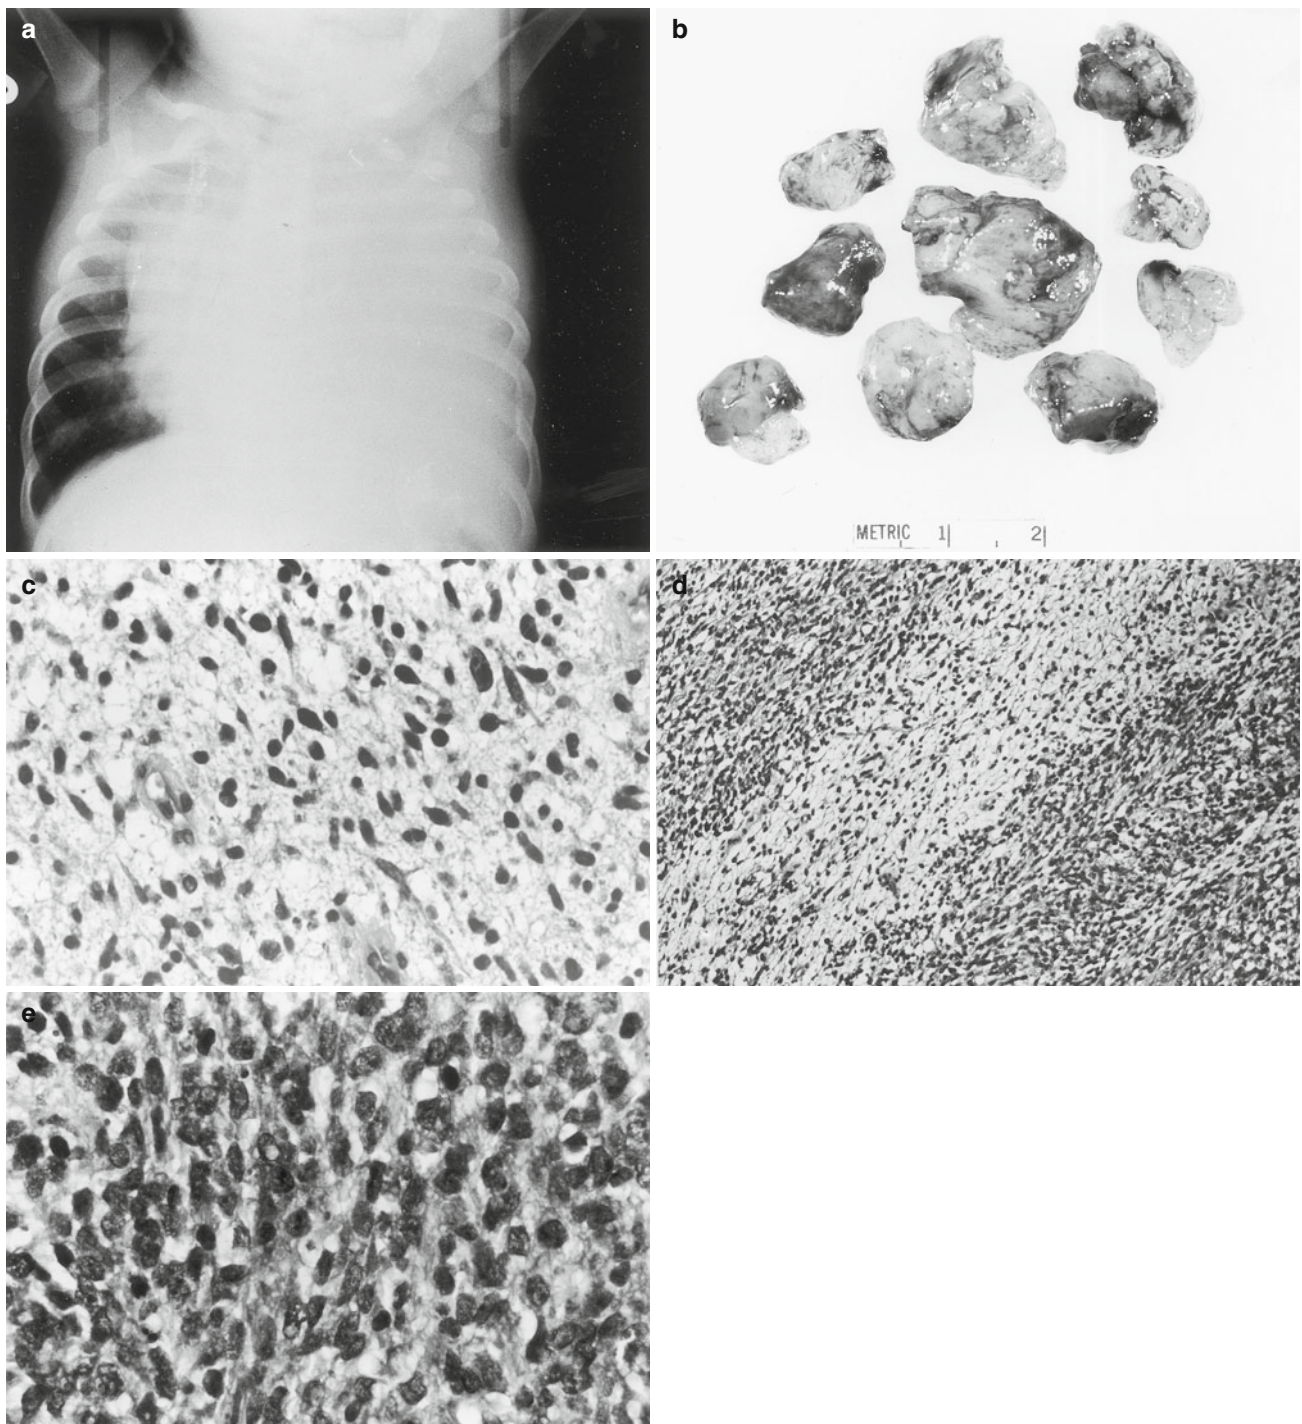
Embryonal rhabdomyosarcoma of the mediastinum. (a) Chest X-ray of an 8-month-old male with a 1-week history of a cough and progressive respiratory distress. Imaging reveals consolidation of the left thorax with displacement of the mediastinum to the left. In the differential diagnosis of a thoracic “white out” consolidation in an infant, the main following neoplastic conditions should be considered: pleuropulmonary blastoma, pleuropulmonary PNET (“Askin tumor”), and rhabdomyosarcoma. Malignant lymphoma is very rare in infants. (b) Biopsy material obtained from the mediastinal mass showing a soft
